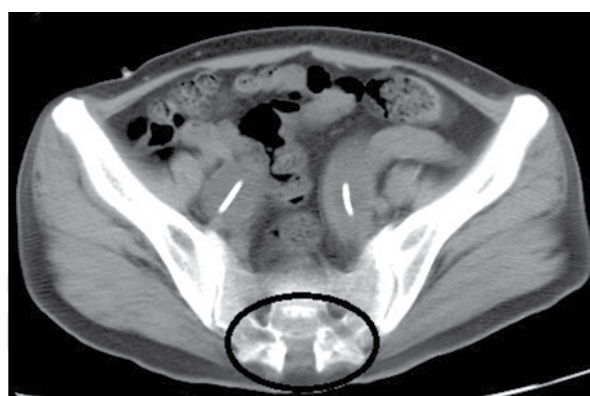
Abdominal computed tomography showing schistorrhachis.
